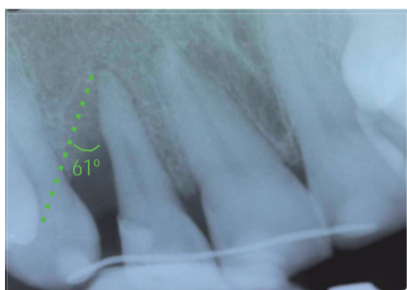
Inicial radiograph. The radiographic defect angle was superior to 37°.
